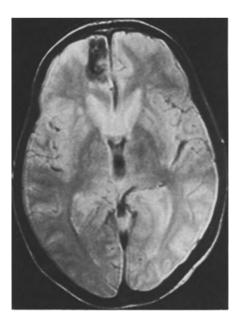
Axial MRI (TR SE 2189 ms, TE 50 ms), showing a right frontal mixture of increased and decreased signal intensity with a prominent border of markedly decreased intensity
